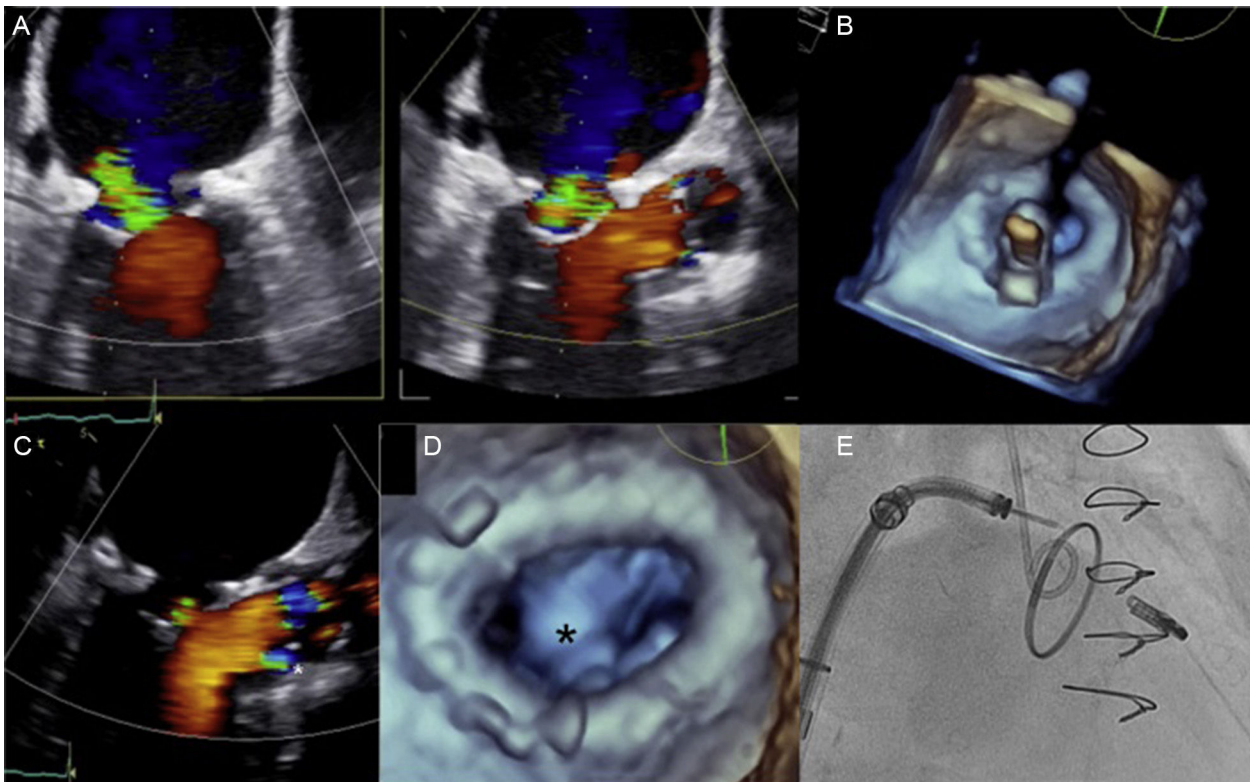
Severe mitral regurgitation following annuloplasty; B: Real-time 3-dimensional transesophageal echocardiogram showing perpendicularity of the clip with respect to leaflets and ring; C: Achievement of mild mitral regurgitation following clip implantation; D: 3-dimensional transesophageal echocardiogram showing a double orifice with the clip in between (asterisk); E: Fluoroscopic image showing the position of the implanted clip in relation to the annuloplasty ring.
